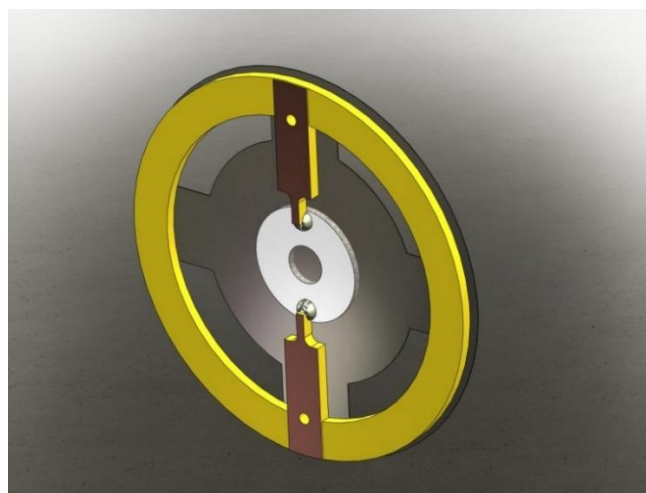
shows the structure of the piezoelectric ultrasonic atomisation unit. Fig 1 (a) and (b) show the unit main components and the assembled CAD design of the unit, respectively. The unit consists of three main components which are the active piezoelectric ultrasonic transducer element, disk and printed circuit board (PCB) ring. The active element is a single flexural vibrating ring made from piezo-ceramics PZT material. The disk is made from steel and has been micro machined with array of micro holes using advanced in Nano and micro laser machining technology. The PCB ring is made from fiber and this is to house the piezoelectric ultrasonic atomisation unit to the passive HME humidification device.
